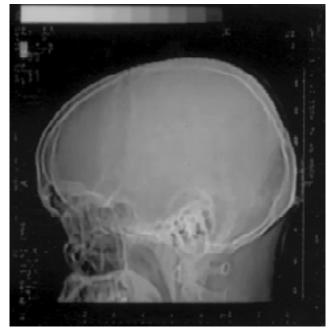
X-ray skull - Khudiram Jena, 35 yr male, earthquake, Gujarat
